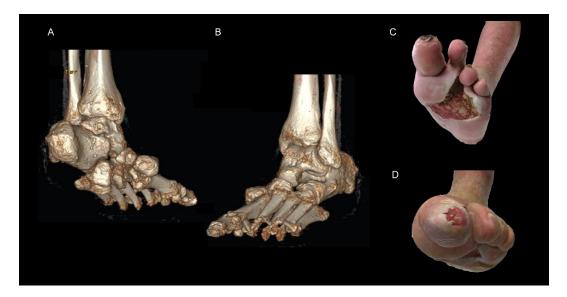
3D CT-scan Charcot foot images: posterior and anterior view (A-B), respectively. Clinical images after soft-tissue debridement sections (C-D).
